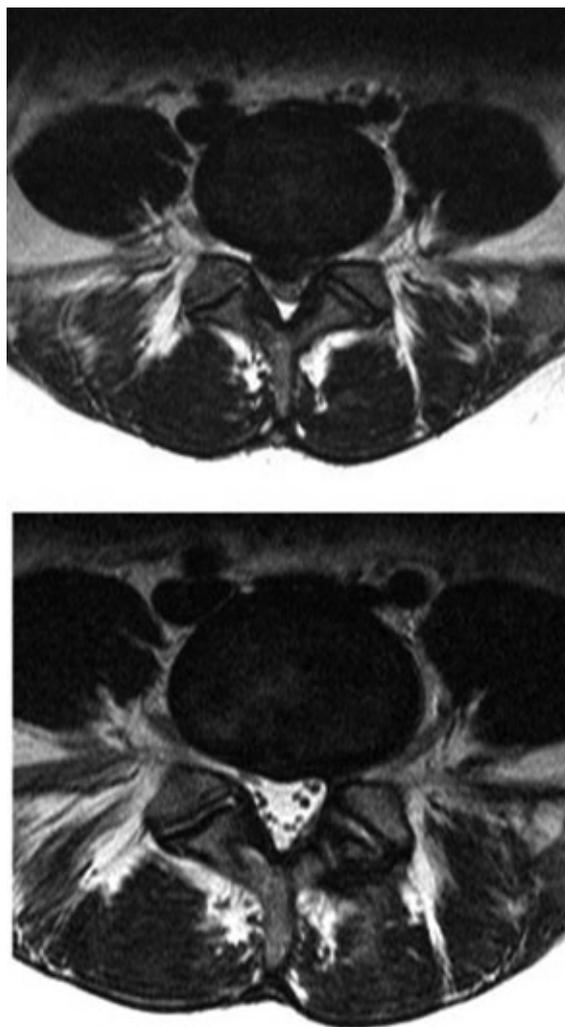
MRI of a study patient demonstrating a posterior L5-S1 disc herniation (top). Postoperative MRI of the same patient after MIM (bottom).
